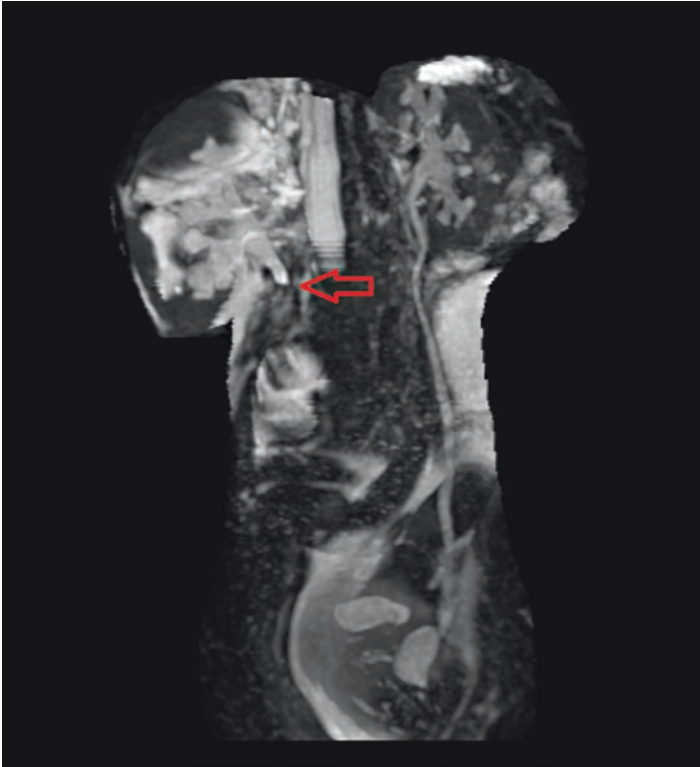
Magnetic resonance imaging (MRI) in a pregnant patient with a right-sided, symptomatic, obstructing stone. The *arrow* indicates a filling defect consistent with a proximal ureteral stone
